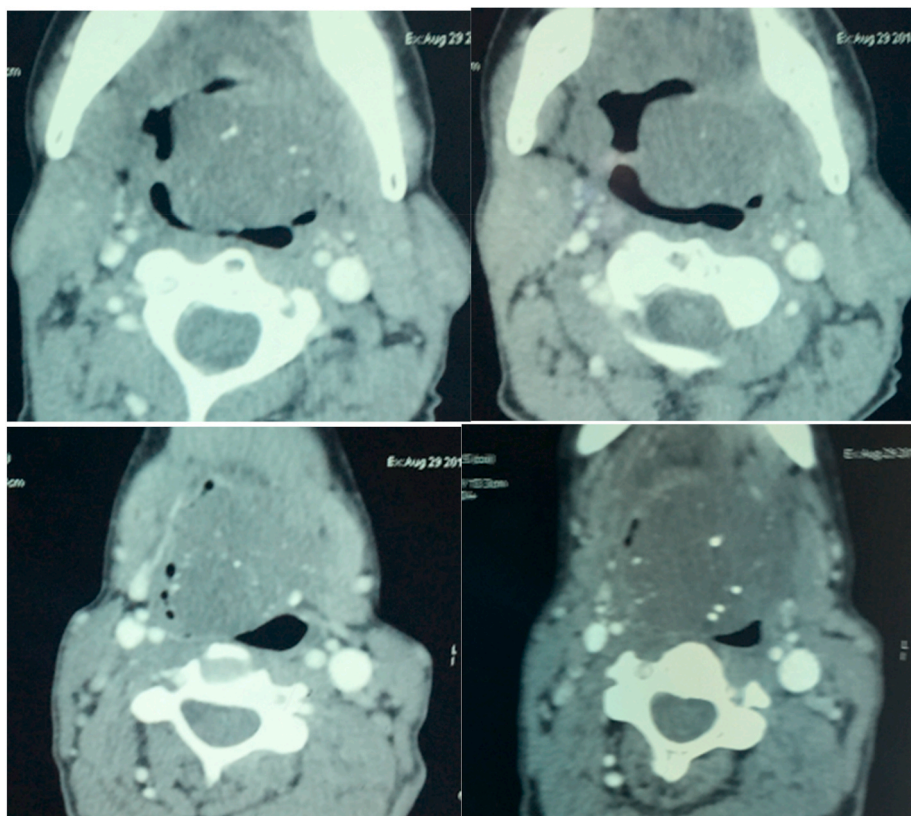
Axial CT images showing the voluminous oropharyngeal mass, located in the tongue base, with inherent micro calcifications.
